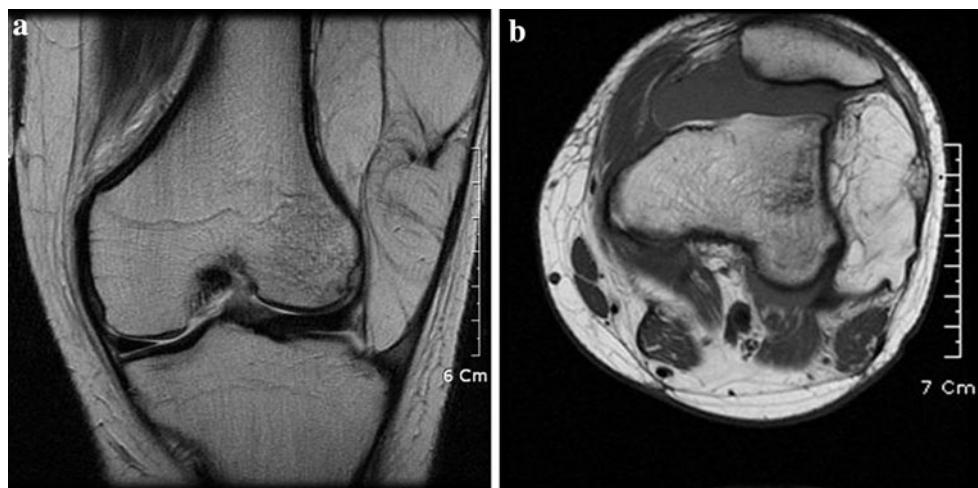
Coronal (a) and axial (b) MRI revealed a large soft tissue mass at the lateral gutter of the knee joint displacing patella. The signal intensity of the mass was similar to the subcutaneous fat tissue
